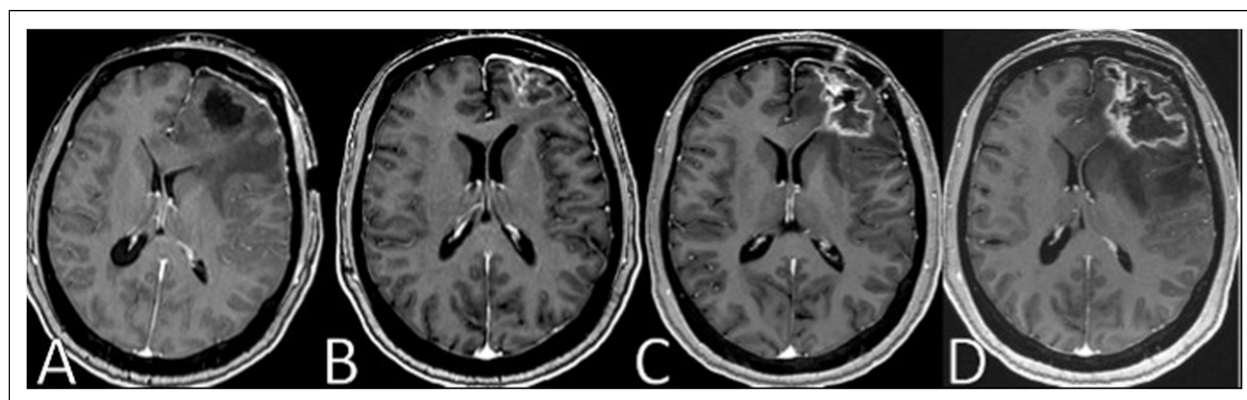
(a) After the first cranial surgery, the post-contrast axial T1-weighted image showed the resection cavity without tumor. (b) At the 9-month follow-up after starting immunotherapy, a prominent peripheral enhancement was observed in the resection cavity with mild peripheral oedema. (c) At the 18-month follow-up, a markedly enhancing mass-like lesion was seen in the resection cavity with peripheral edema. There is no evidence of perfusion. (d) There was a markedly increased enhancing mass-like lesion within the surgical bed with prominent peripheral edema.
